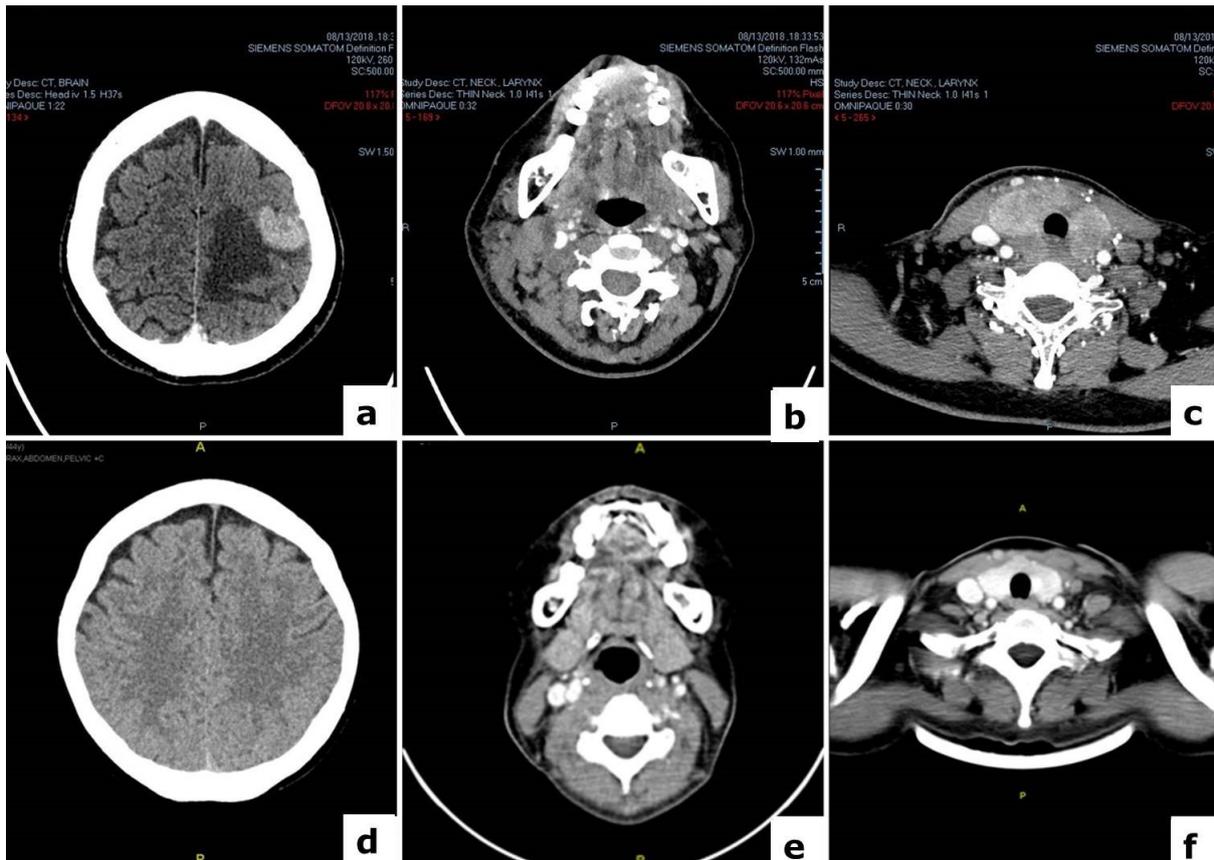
Contrast enhanced CT images comparing lesions at diagnosis (a-c) and at six months post ceritinib (d-f) showing (a) Left frontal lobe lesion (b) Right cervical lymph nodes (c) Enlarged thyroid gland which have regressed significantly post treatment (d-f). (Click to enlarge)
